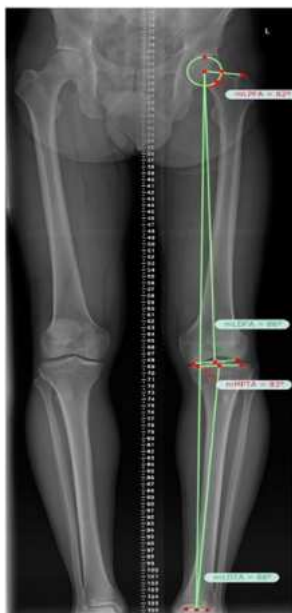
A long leg radiograph of the left leg. A true AP projection of the tibiofemoral joint has been achieved. The Miculicz line from the centre of the femoral head to the centre of the ankle is shown. Measurement variables in the coronal plane are shown; mLPGA, mL DFA, mMPTA, mLDTA. Measurements obtained using TraumaCad®(Brainlab, Westchester, USA).
